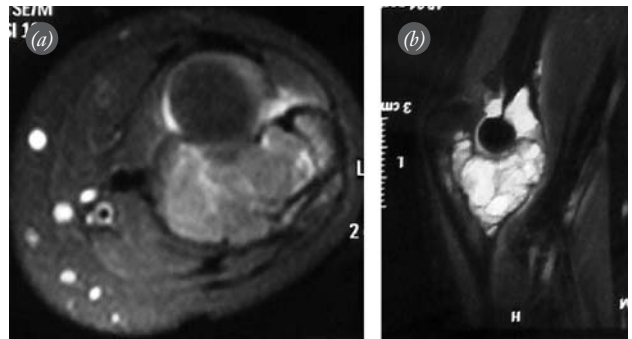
(a) Axial T1-weighted MRI showing the coronoid process involved by the tumor. (b) Sagittal T2-weighted MRI showing the coronoid process enlargement due to aneurysmal bone cyst.
